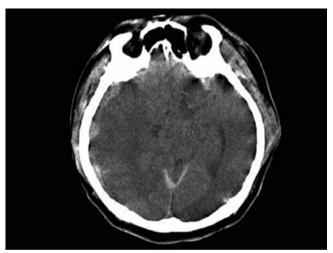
Computed tomography (CT) in Case 1. Head CT shows acute subdural hematoma with compression of the basal cisterns.
